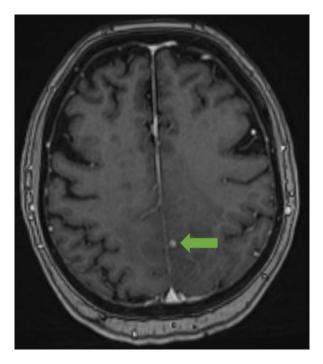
Axial projection of a contrast enhanced T1 weighted MRI Brain showing a 4mm enhancing nodule in the left parasagittal parietal lobe.
